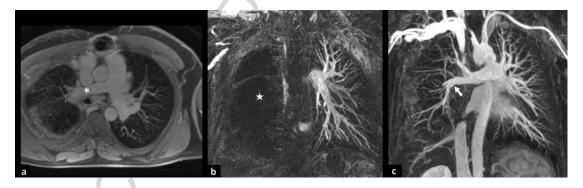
The apparent right PA filling defect is not present on post contrast (90 sec) T1 fatsuppressed VIBE (3D Volumetric interpolated breath-hold examination) sequence MRI of the thorax (white asterisk).
